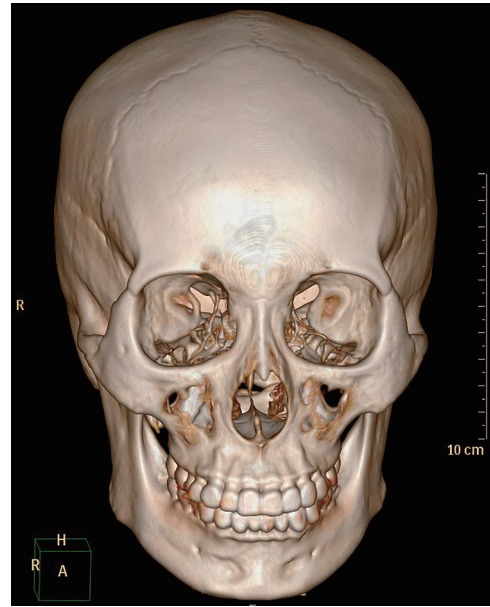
Additional case 5. Three-dimensional reconstruction of the computed tomographic scans from a 31-year-old woman. She could not remember the exact injection-related information. Evident bony resorption could be found in bilateral incisive fossa.
